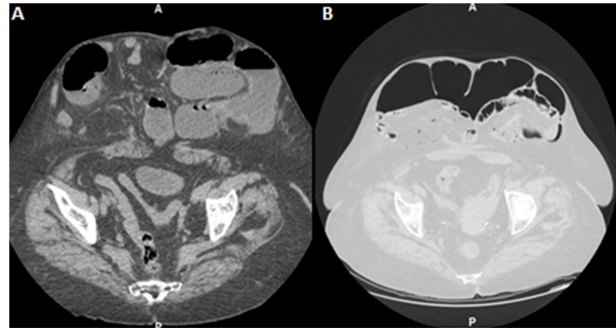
Simple abdominopelvic CT. A) Axial section prior to prehabilitation. B) Axial section after PPP.
